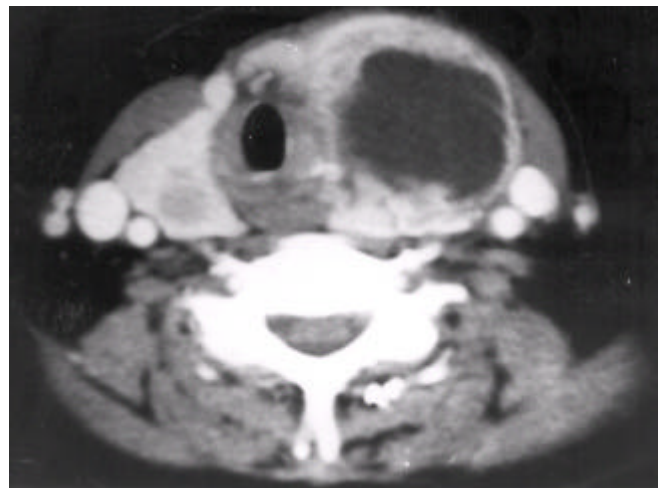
CT imaging of the patient showing bilateral nodular lesions in the thyroid gland at admission
